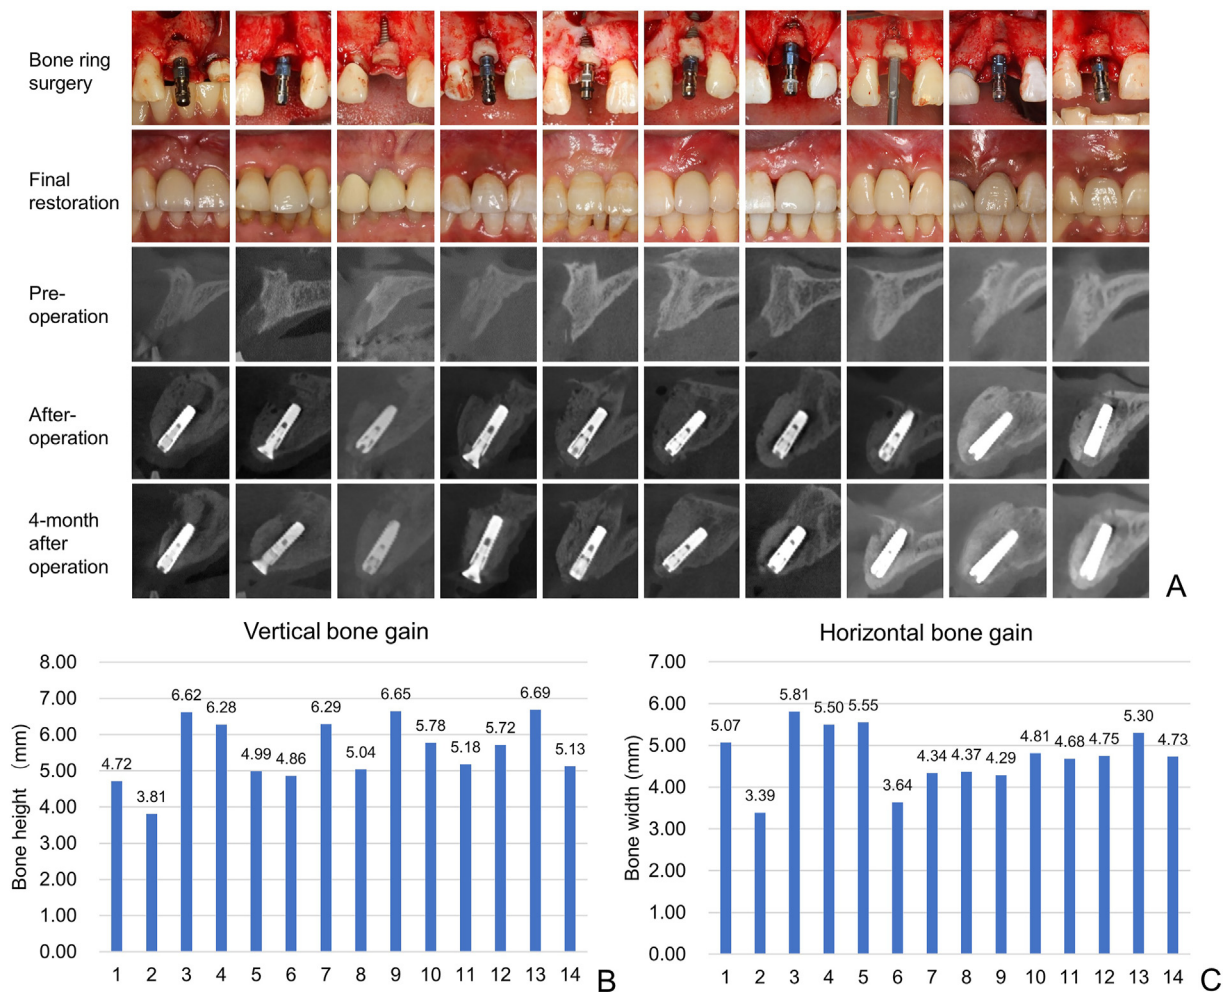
BRT treatment procedure and vertical/horizontal bone gain in each patient included in the analysis. A. Representative photos from these patients’ surgeries and radiographs during different follow-up periods. B. Vertical bone gain values after 4 months post-surgery as measured by CBCT. C. Horizontal bone gain values 4 months post-surgery. BRT, bone ring technique; CBCT, cone-beam computed tomography.
